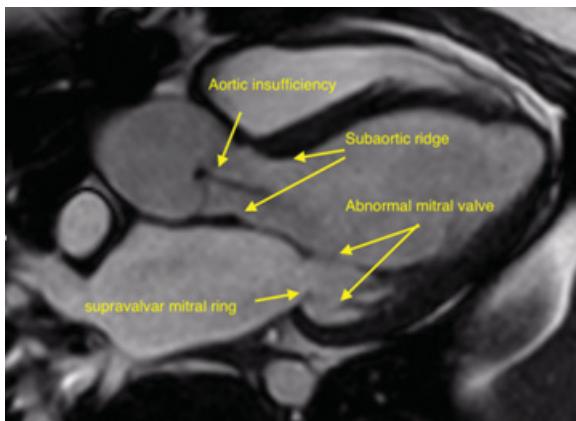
Multiple left-sided lesions. Three-chamber magnetic resonance imaging showing supravalvular mitral ring, hypoplastic mitral valve annulus, abnormal mitral valve, small subaortic ridge, and aortic regurgitation. Courtesy of Michael Taylor, MD.
